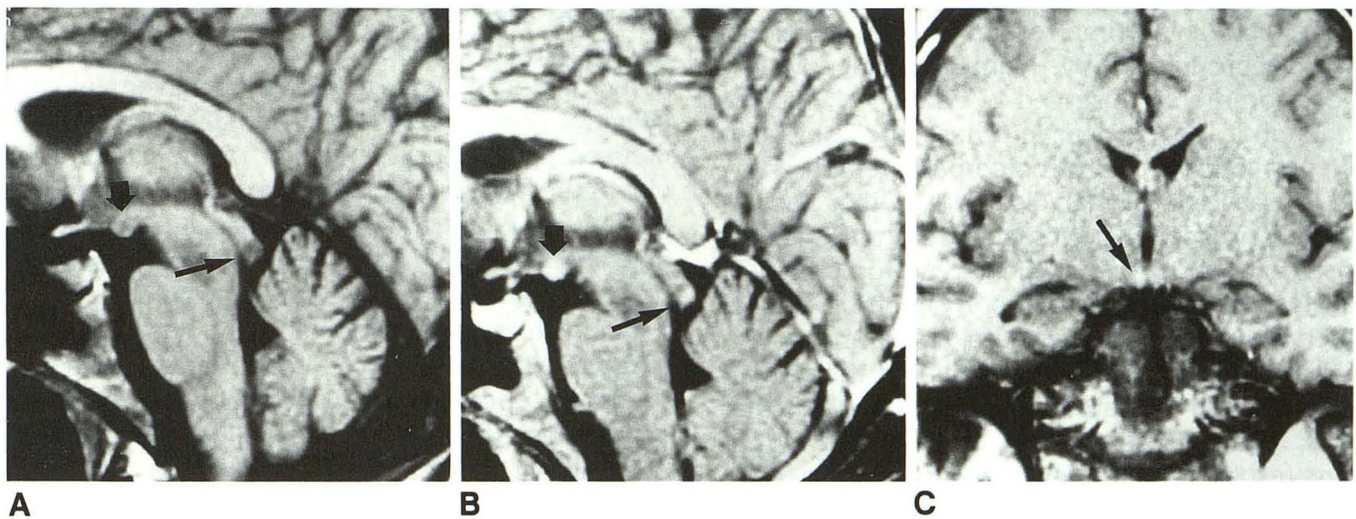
T1-weighted gradient-echo (320/15 [repetition time/echo time], 90° flip angle) images in the midsagittal plane before (A) and after (B) administration of gadopentetate dimeglumine. Note the hypodense area at the level of the mamillary bodies (*wide arrow*) and inferior to the quadrigeminal plate (*thin arrow*) with enhancement after contrast. The coronal plane after contrast (C) shows the enhancement of the mamillary bodies (*arrow*).
